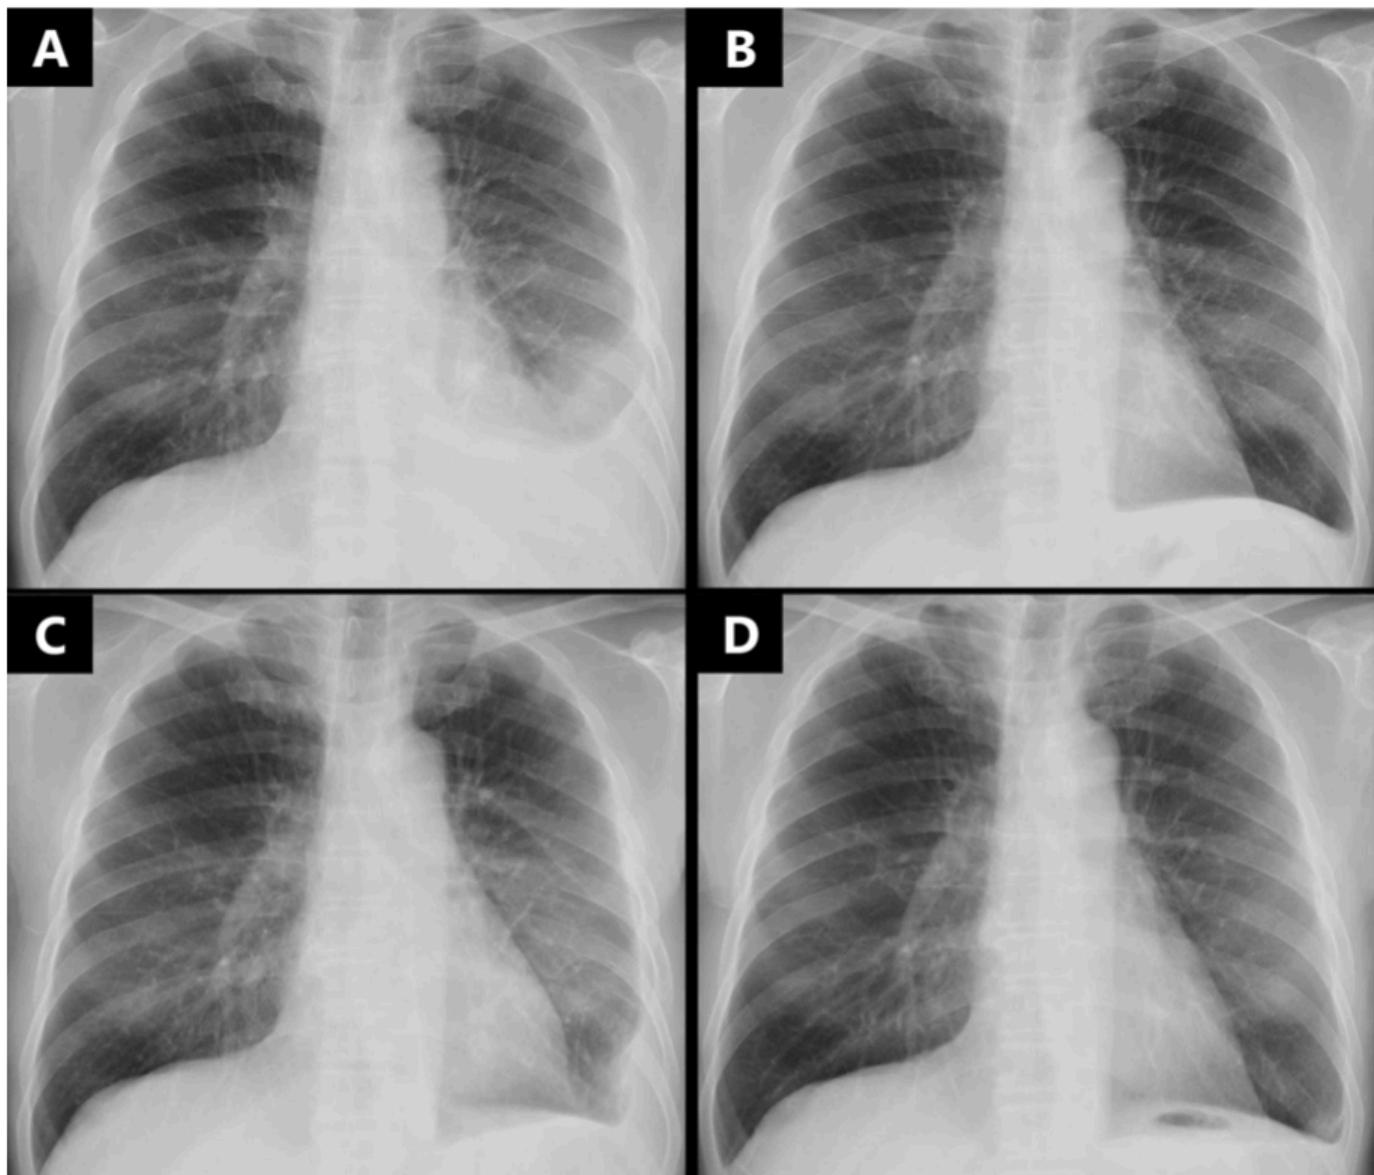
Changes in rheumatoid pleural effusion (RPE) observed via chest X-ray.
